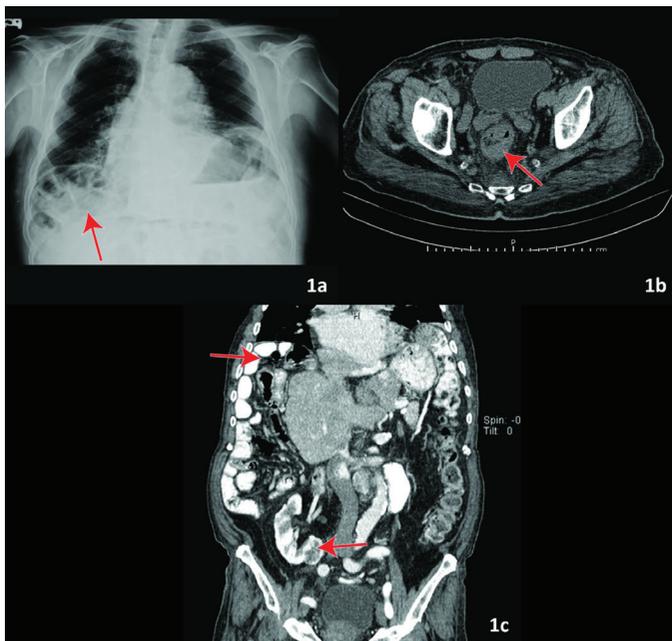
a) On anterior-posterior chest X-ray, the elevation of the right hemi-diaphragm and air under the diaphragm (indicated by the arrow), b) pelvic cut of the computed tomography (CT) scan showing thickened rectal wall (indicated by the arrow), c) CT scan coronal view showing the right-sided renal cell carcinoma and Intestinal loop transposed between the diaphragm and the liver (indicated by the arrow)
